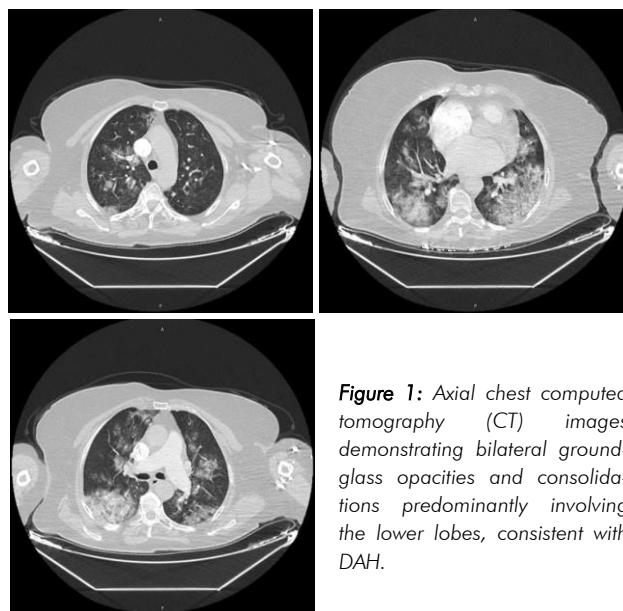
Axial chest computed tomography (CT) images demonstrating bilateral ground-glass opacities and consolidations predominantly involving the lower lobes, consistent with DAH.
